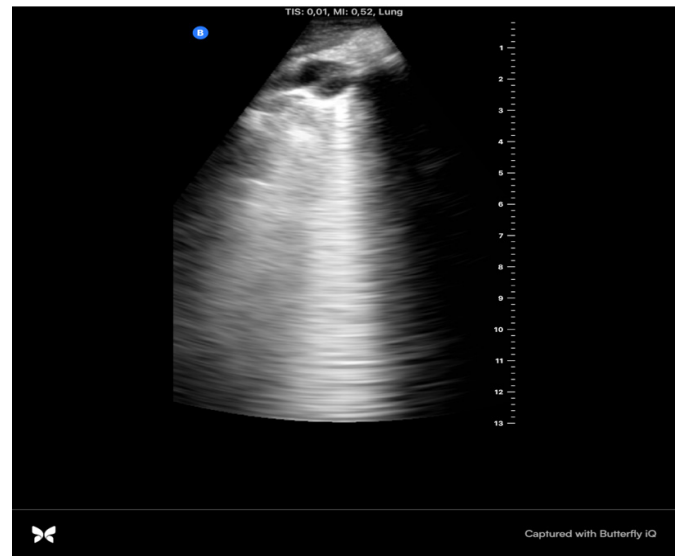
Lung ultrasound image obtained from the right upper lung zone demonstrating multiple vertical hyperechoic artifacts consistent with B-lines, attributed to pleural involvement secondary to malignant pleural mesothelioma
